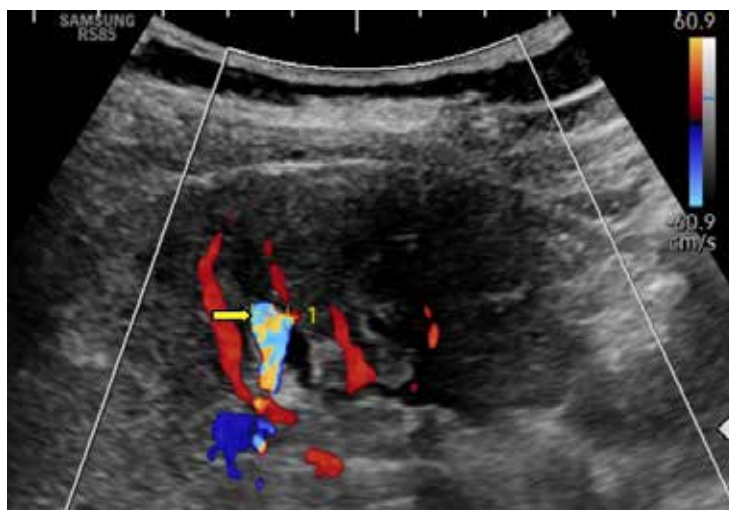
Doppler ultrasonogram showing an area with a twinkling artifact (arrow)
